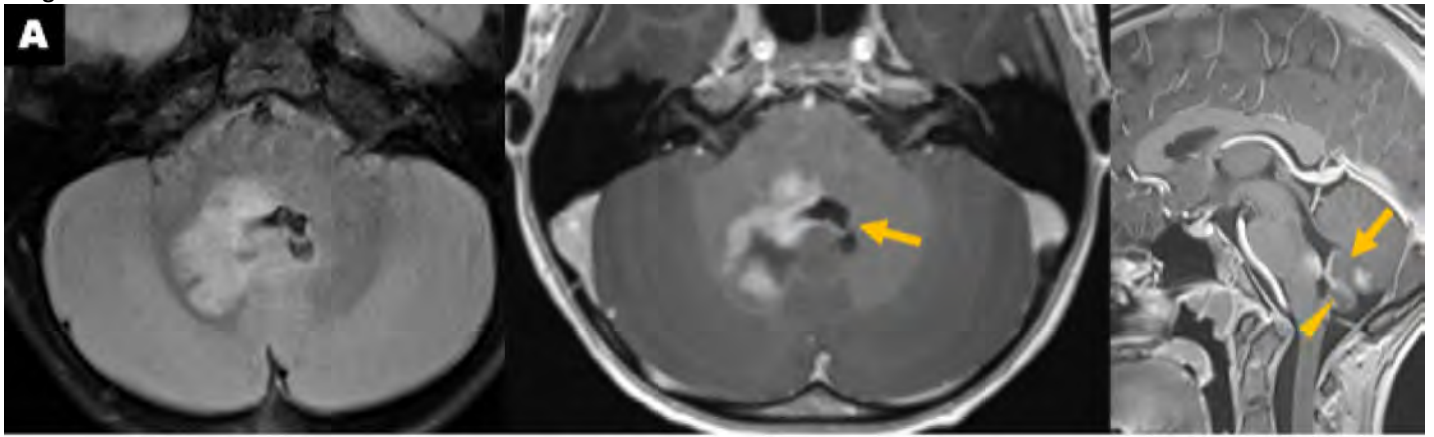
Cladophialophora bantiana* meningoencephalitis and ventriculitis in a 9-year-old. Axial FLAIR (A), axial T1 post-contrast (B), and sagittal T1 post-contrast (C) show necrotic ring enhancement and ependymal spread.
